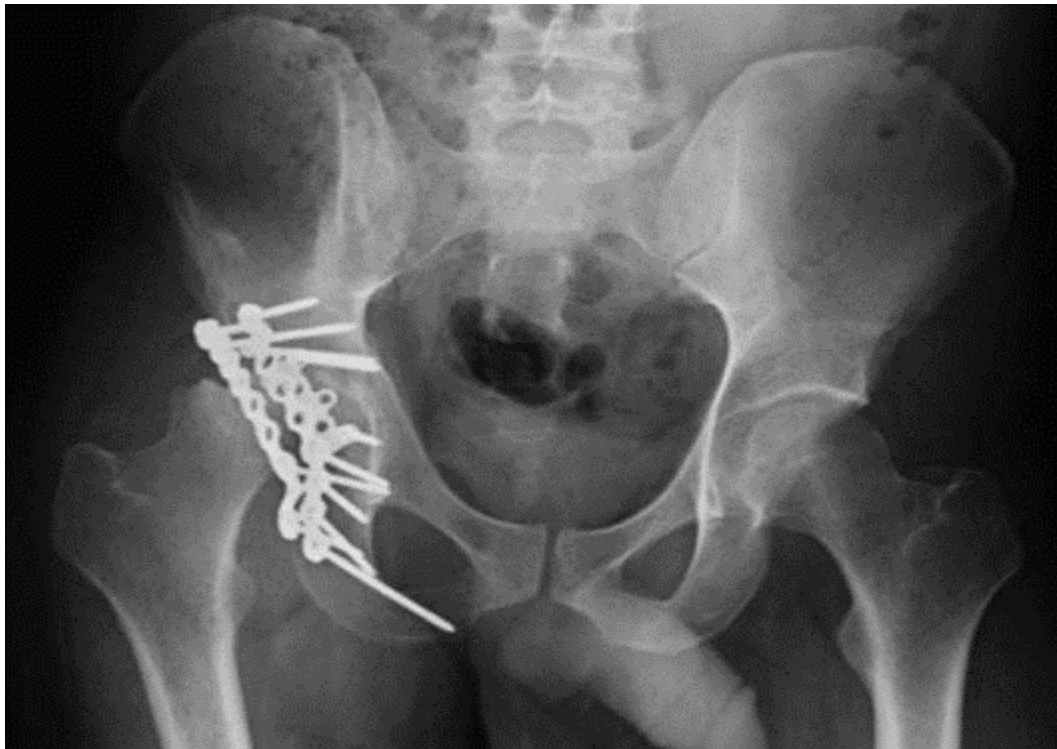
This Xray pelvic view showing avascular necrosis and osteoarthritis of hip joint. ⁽⁷⁾
